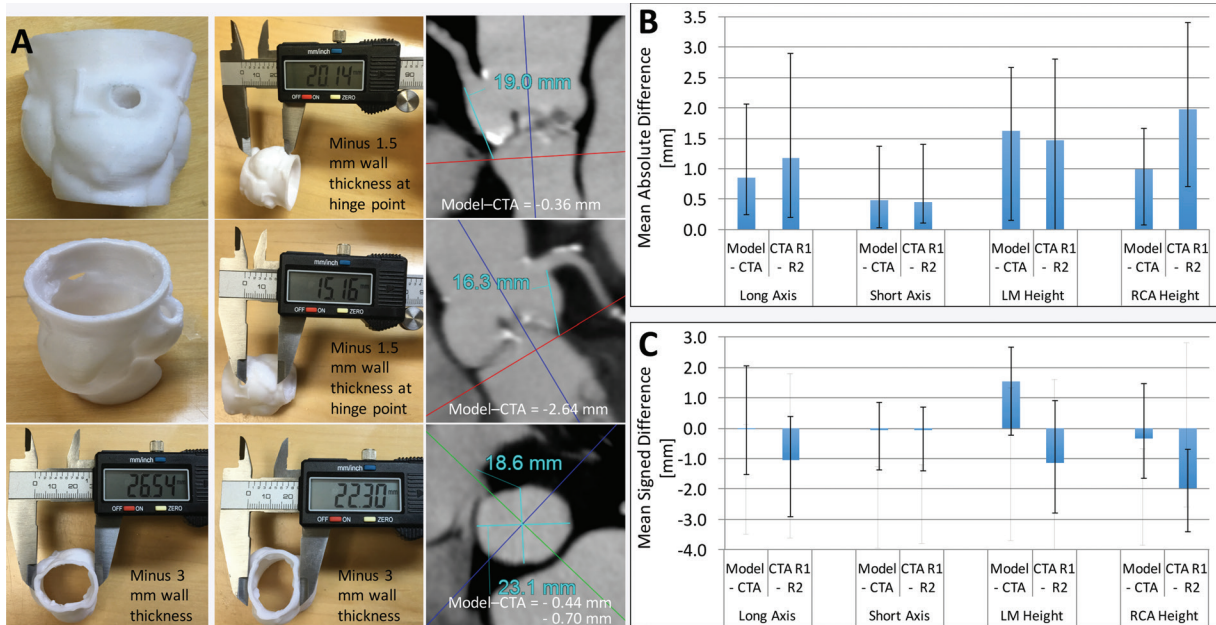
Printed 3D model versus image measurements of the aortic valve. *A*, Caliper measurements performed on a 3D printed model of the aortic valve and radiologist measurements performed on source CT angiograms (CTA) demonstrate individual differences in coronary artery heights and aortic annulus diameters between the model and angiograms. *B*, Graph data show that in 10 patients, mean absolute differences in these measurements were within the range of interobserver variability in CT angiographic measurements. *C*, Graph data show that the use of mean signed differences led to an overestimation of the accuracy of the 3D printing process, as the positive and negative differences for different patients canceled each other. Error bars indicate the maximal differences across the 10 patients. *LM* = left main coronary artery, *RCA* = right coronary artery, *R1* = reader 1, *R2* = reader 2.
